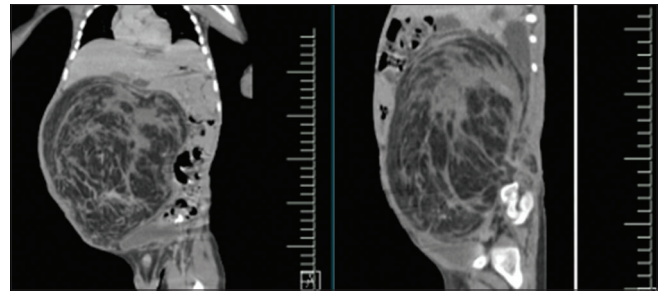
Positron emission tomography-computed tomography images showing a large heterogenous mass lesion in the right anterior pararenal space
